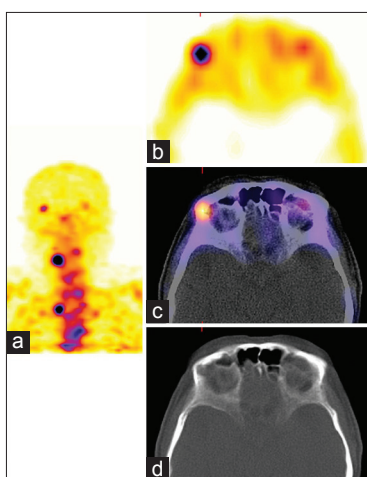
A 60-year-old male with an enlargement of the lacrimal gland (a) Maximum intensity projection. (b-d) Single-photon emission computed tomography/computed tomography SPECT/CT slice, respectively, through the fossa of the lacrimal gland
